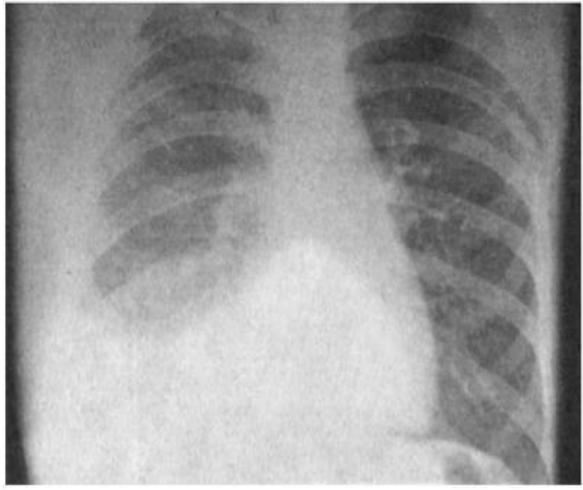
Figure to task 6. X-ray of patient A., 23 years
